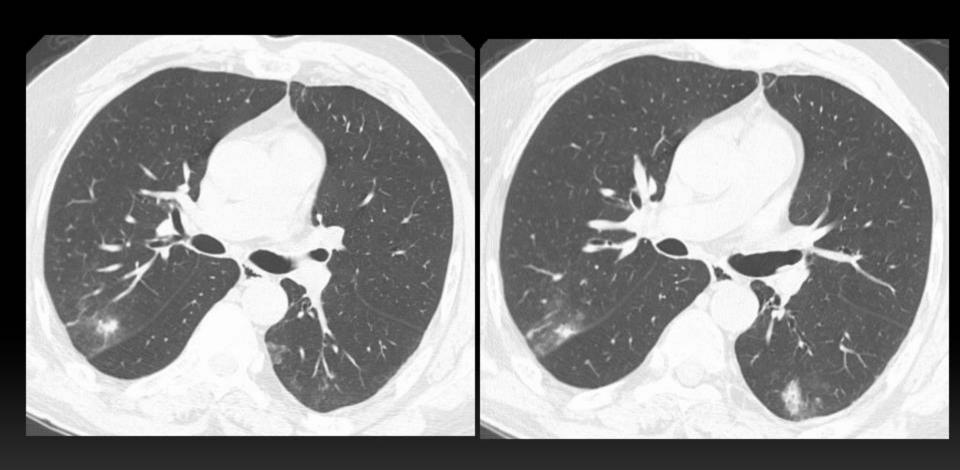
Man, 40 years, immunocompromised cough and hemoptysis. Thoracic CT discloses nodular opacities surrounded by a halo of ground-glass opacity in the posterior segment of right upper lobe and superior segment of the left lower lobe. BAL positive for *Aspergillus*.
